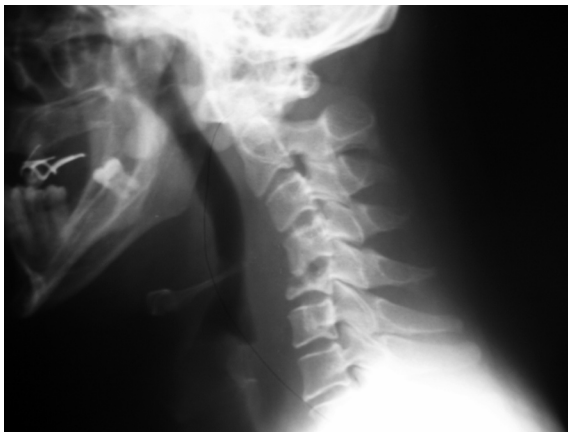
Lateral cervical radiography shows marked decrease in the height of the 5th vertebrae corpus in consistency with compression fracture.
